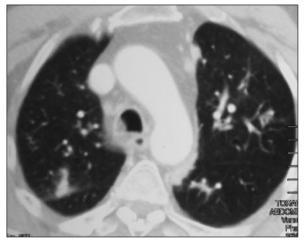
Multiple consolidation areas on thorax computed tomography after three years.
